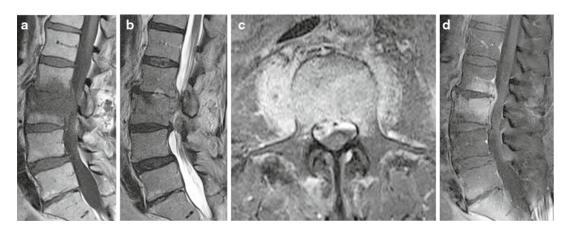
Imaging findings associated with spondylodiscitis. A 65-year-old man with a history of recent abdominal surgery and postoperative sepsis now presents with back pain and right lower limb weakness. Sagittal T1 (a)weighted and T2 (b)-weighted MRI images show T1 hypointensity bridging the L2 and L3 vertebral bodies. The central canal is narrowed. Postgadolinium axial (c) and sagittal (d) images show enhancement in the vertebral bodies, epidural space, and paraspinal tissues consistent with spondylodiscitis. Culture revealed *S. aureus* infection
